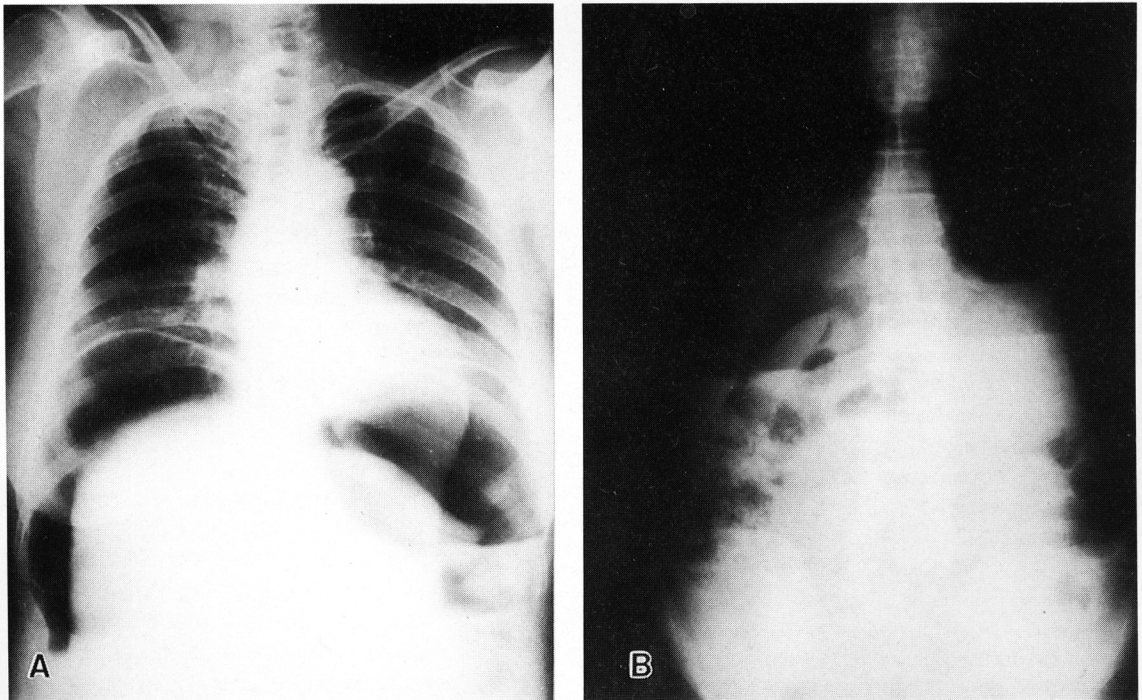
Simple roentgenograms of the chest (A) and abdomen (B), showing extremely large amounts of intraperitoneal free air.
